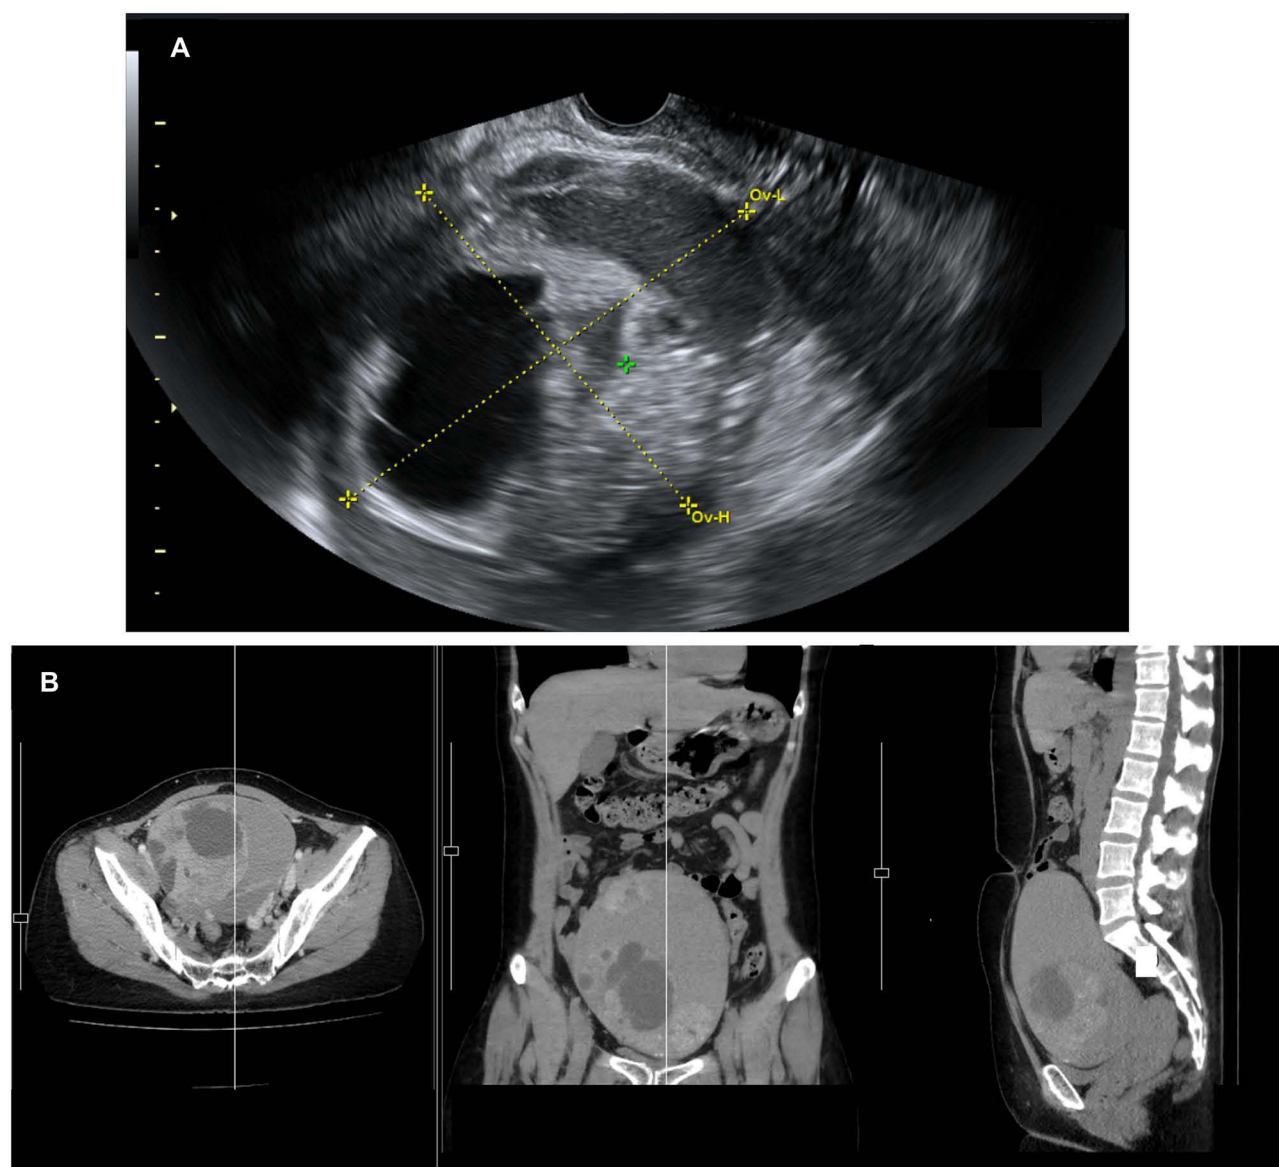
Preoperative imaging of the ovarian mass. (A) Transvaginal ultrasonography revealed a cystic-solid mass measuring $15.76 \times 11.10 \times 14.95$ cm. The green cross is placed at the ovarian tumor, and the yellow lines represent the electronic calipers used to measure the size and dimensions of the mass. (B) The thoracic-abdomino-pelvic CT scan revealed a large well-defined cystic lesion with a multilocular and enhancing solid component or calcification at left adnexal region.
